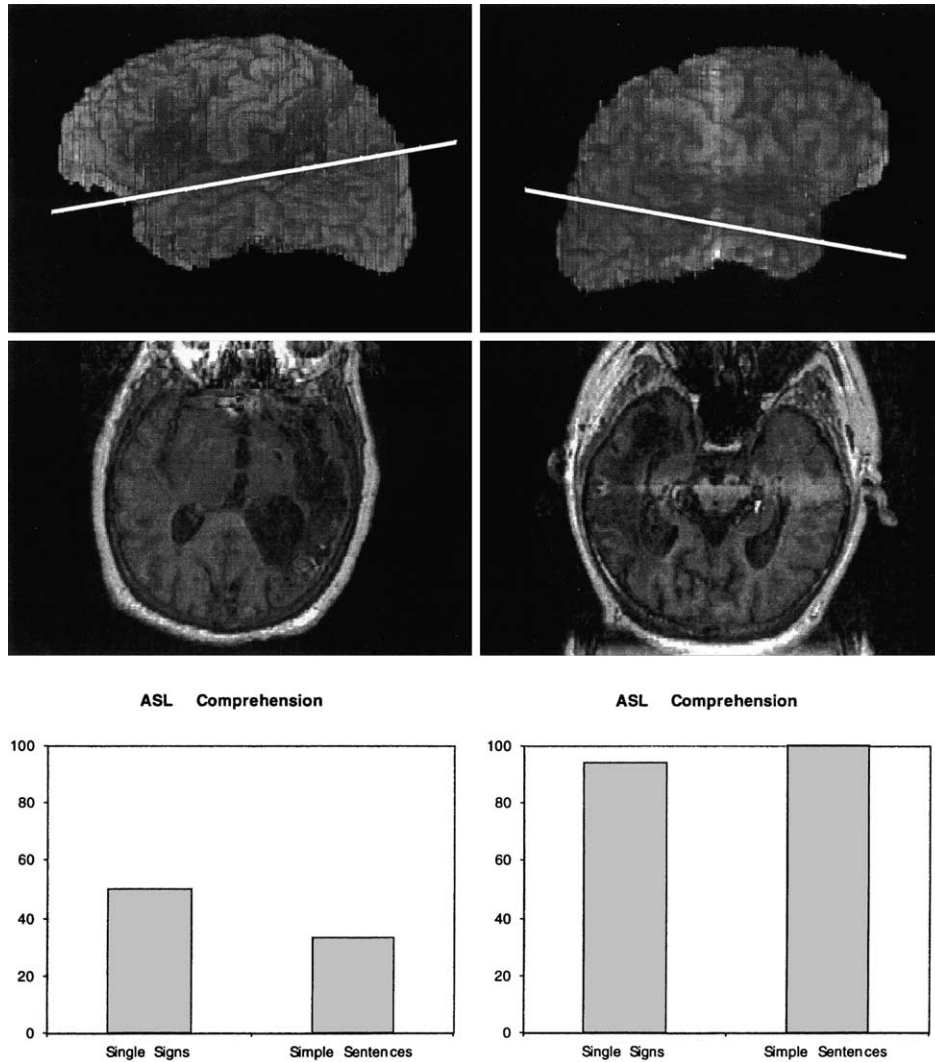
Brain lesions as indicated by chronic MRI scans and comprehension scores (% correct) in one LHD and one RHD deaf signer. The level of the para-axial slice is indicated by the line on the surface reconstruction. In both cases the superior temporal lobe is substantially involved, particularly in the RHD signer whose lesion compromises the entire superior and middle temporal gyri. The distribution of the RHD signer's lesion corresponds to the right temporal lobe regions which were activated in the Neville et al. (1998) study. Despite the similar degree of temporal lobe and perisylvian damage in the two cases, only the LHD signer presents with significant impairment in ASL comprehension. The RHD case was congenitally and prelingually deaf and a native user of ASL.
